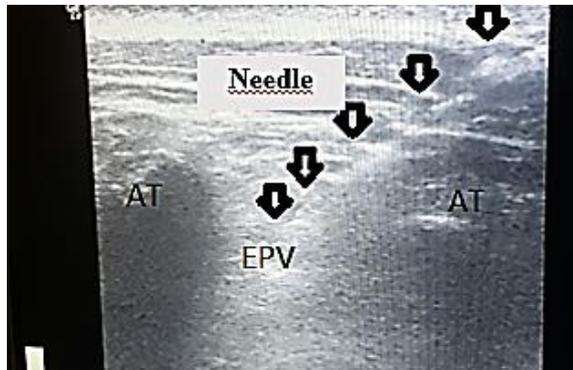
Ultrasound images showing the visualization of Tuohy's needle and its progression, in the ultrasound plane, towards the para vertebral space.
